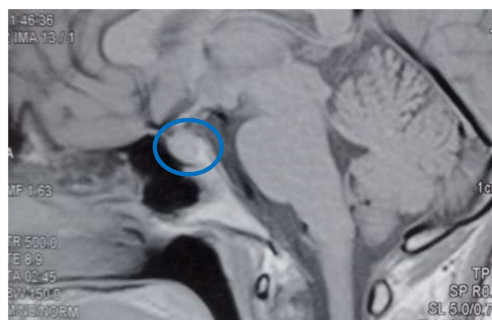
MRI: Sagittal section of a round hypodense formation on T2, measuring 6.8 mm along its major axis, deforming the sellar diaphragm.
